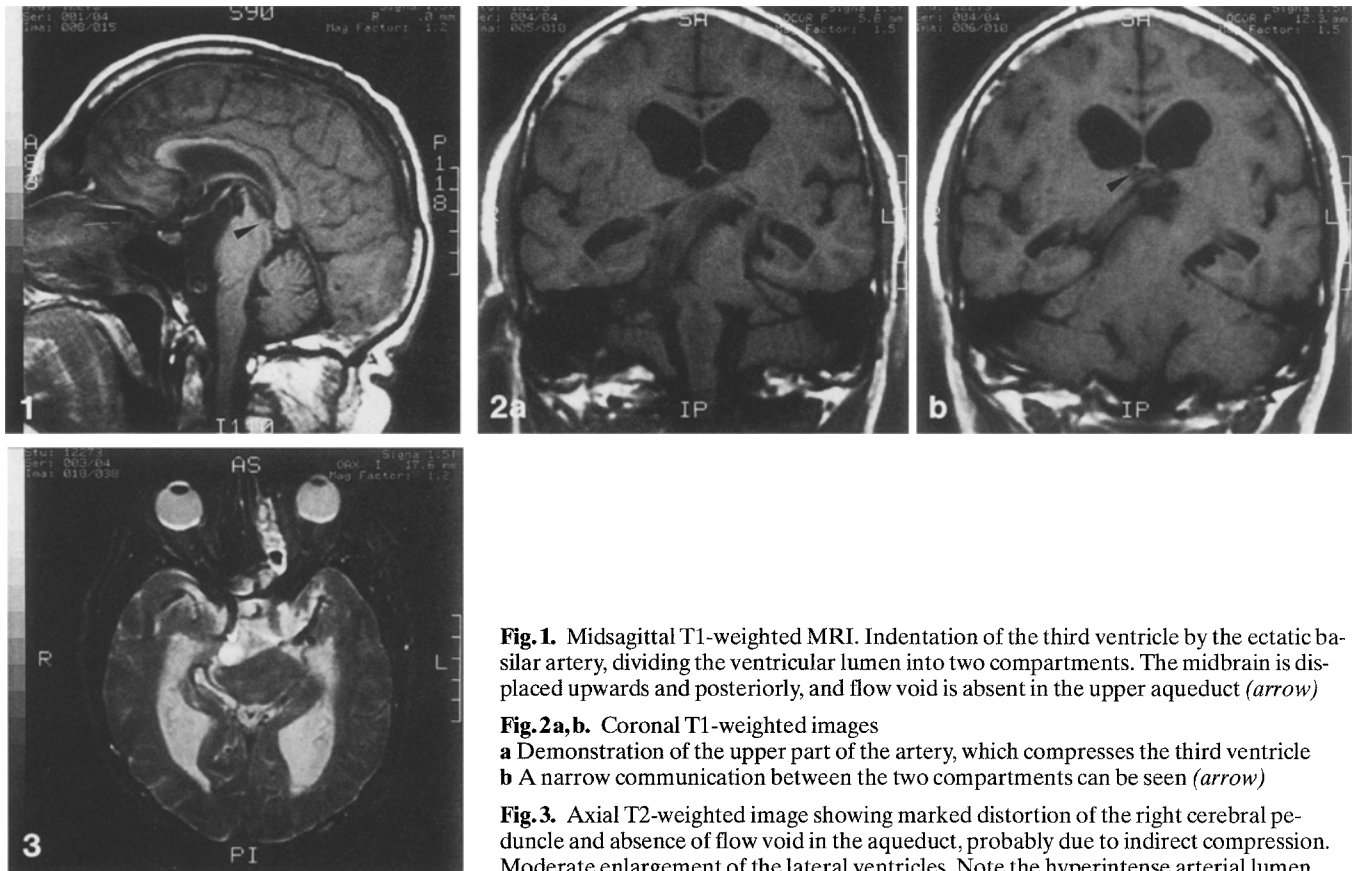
Midsagittal T1-weighted MRI. Indentation of the third ventricle by the ectatic basilar artery, dividing the ventricular lumen into two compartments. The midbrain is displaced upwards and posteriorly, and flow void is absent in the upper aqueduct (*arrow*)
